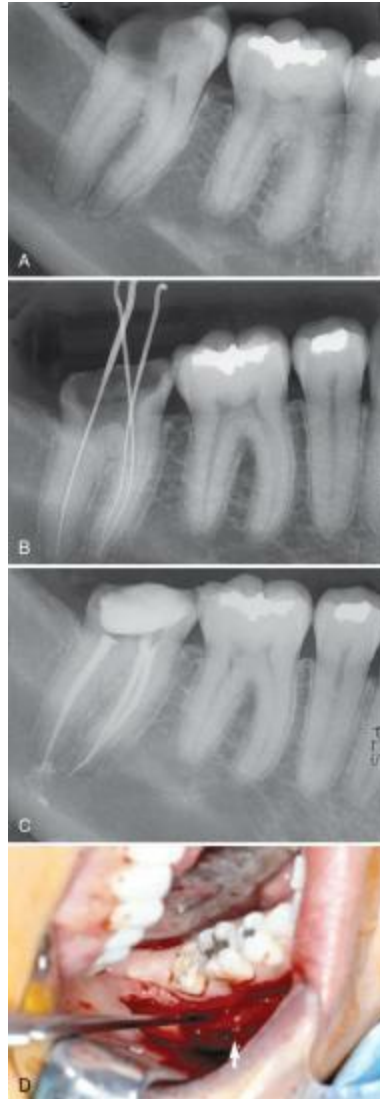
A, Preoperative radiograph. B, Measuring film without a rubber dam. C, Postoperative radiograph. D, Decompression microsurgery showing protruding “dagger” of bone to right of retractor at inferior border of inferior alveolar nerve, resulting from prior perforation of the mandibular canal. This is probably due to file overinstrumentation.
